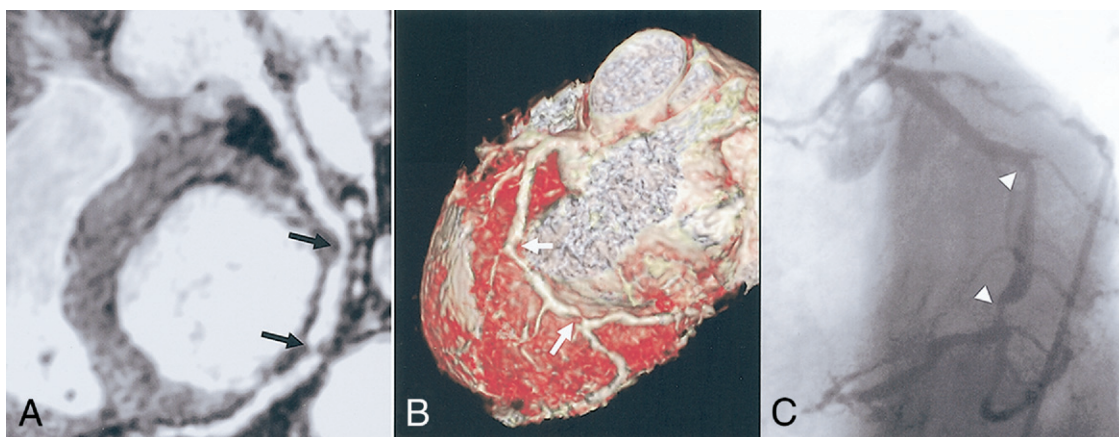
A patient with stenosis in the left circumflex (LCX) artery. (A) Curved multiplanar reconstruction demonstrates stenoses of LCX in 2 locations (black arrows). (B) Volume rendering method shows 3-dimensional view of LCX with stenoses (white arrows). (C) X-ray coronary angiography of the same artery confirms stenoses of LCX (arrowhead).
